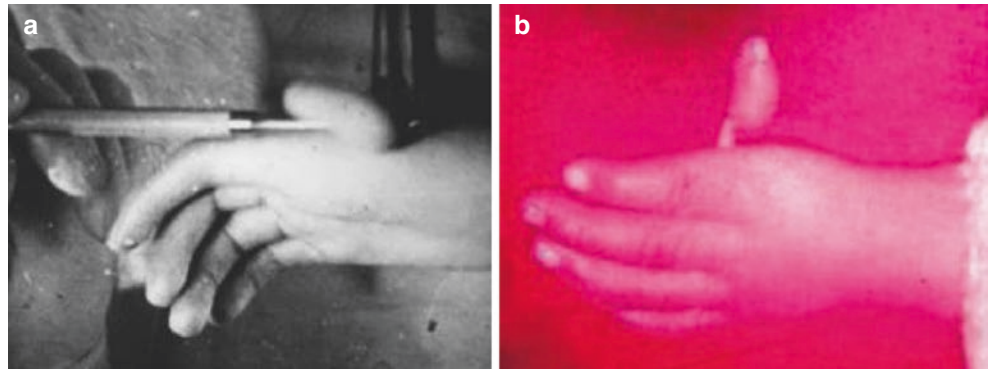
Type IV thumb dysplasia (floating thumb). (a, b) The left hand suffers serious dysplasia of thumb, close to the floating thumb, and the right hand type suffers VII deformity of duplication of the thumb (c, d). The X-ray film displays the right hand suffers type VII duplication of the thumb
